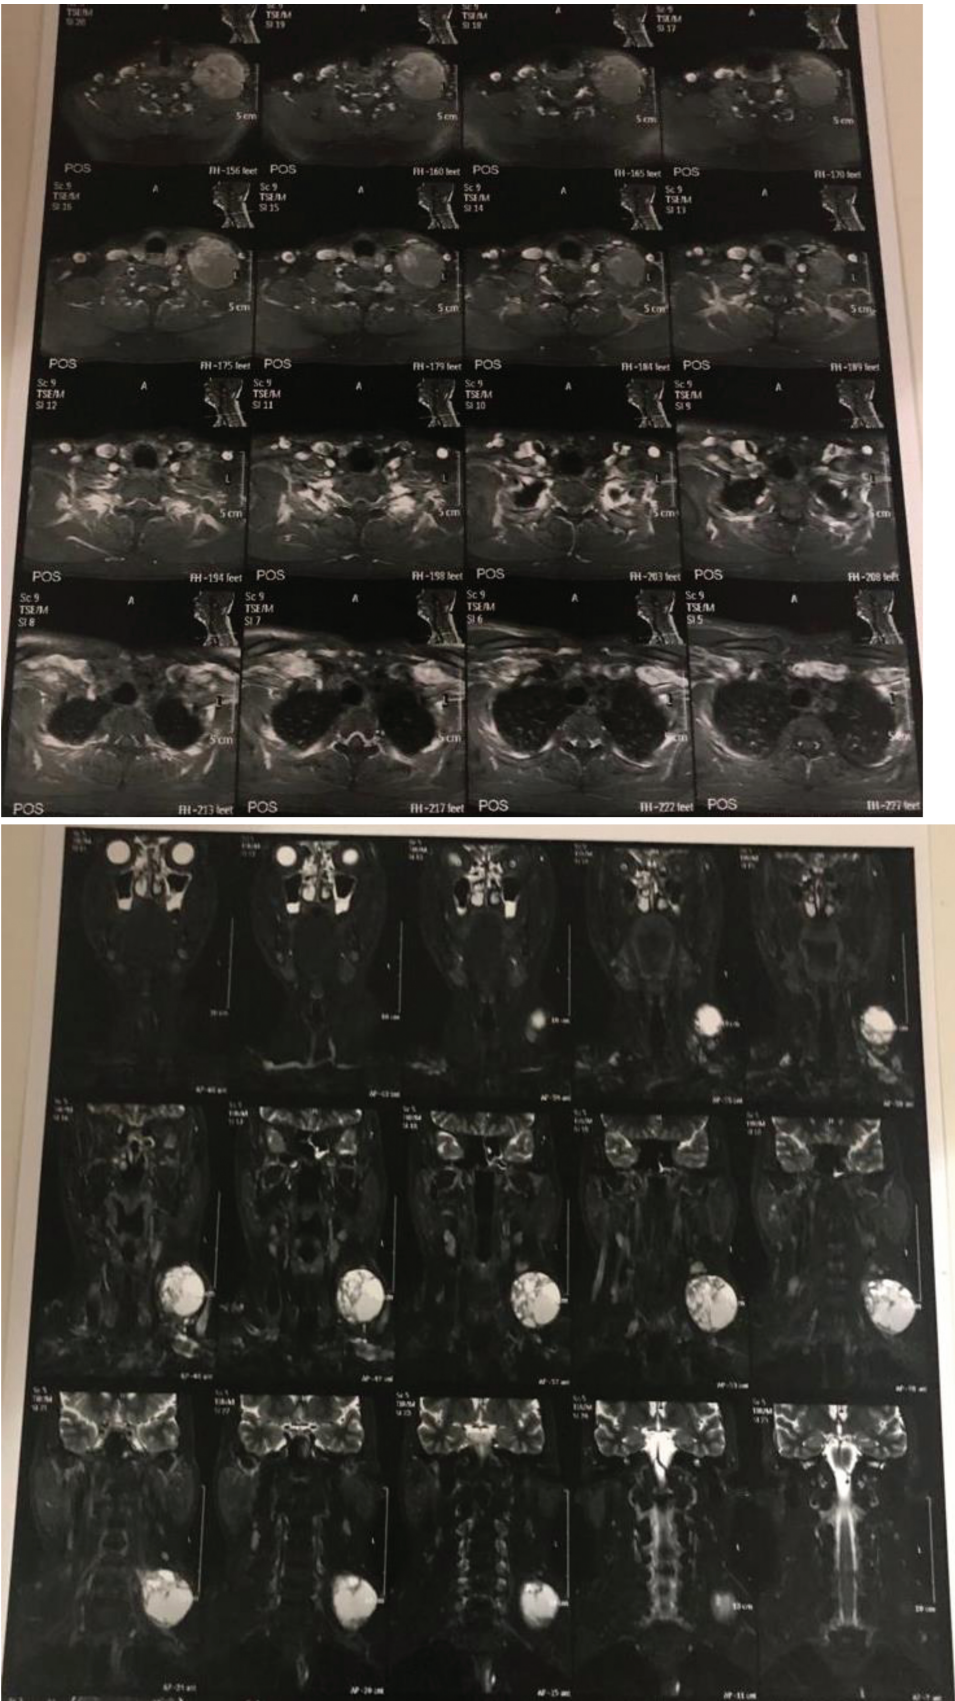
Magnetic Resonance Imaging showing left brachial plexus schwannoma in axial view (a) and coronal view (b).
